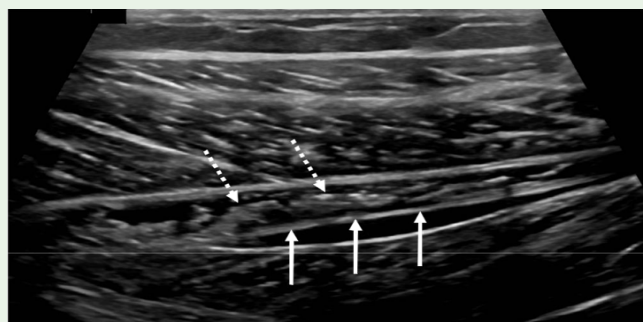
Longitudinal US medial right calf post adhesiolysis of plantaris tendon showing posterior peritendon scar (dotted arrows) resulting in the thickened appearance of the plantaris tendon on MRI. The plantaris tendon (arrows) and medial soleus and gastrocnemius aponeuroses are normal. Compensatory lateral calf overload, with physiological de-loading of the medial calf, was thought to underlie lateral calf symptoms in this case. 20cc normal saline was used for adhesiolysis and the athlete was able to resume full training at 1-week post procedure.
